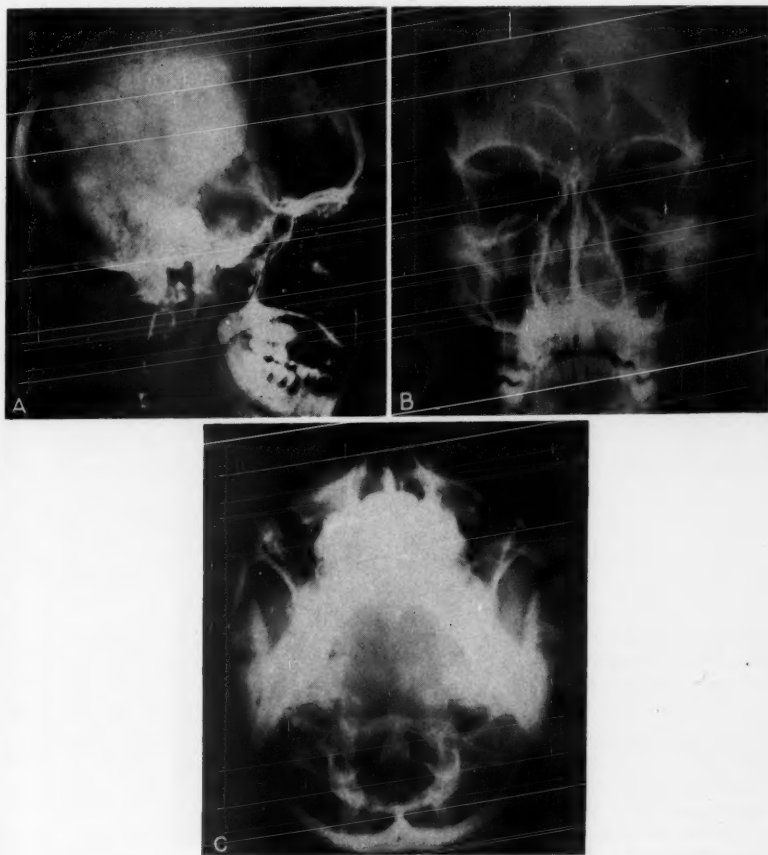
Preoperative roentgenograms in 1950.
